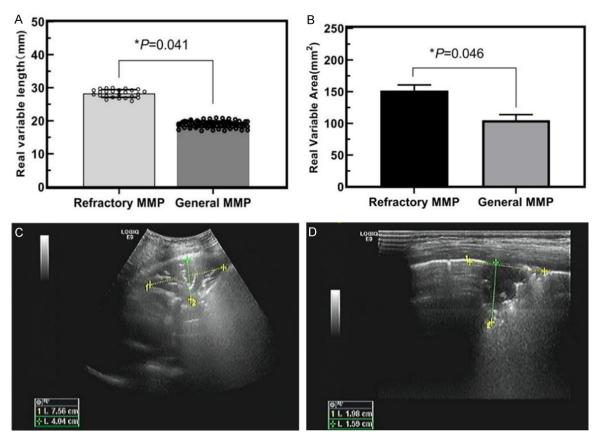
Comparison of length and area of parenchymal lung lesions in children with MPP. Note: A. Comparison of length of parenchymal lung lesions in children with general and refractory mycoplasma pneumoniae pneumonia (MPP); B. Comparison of area of parenchymal lung lesions in children with general and refractory MPP; C. Ultrasonic pictures of the lungs of refractory MPP, length: 75.6 mm, area: 75.6 mm × 40.4 mm; D. Ultrasonic pictures of the lungs of general MPP, length: 19.8 mm, area: 19.8 mm × 15.9 mm.
